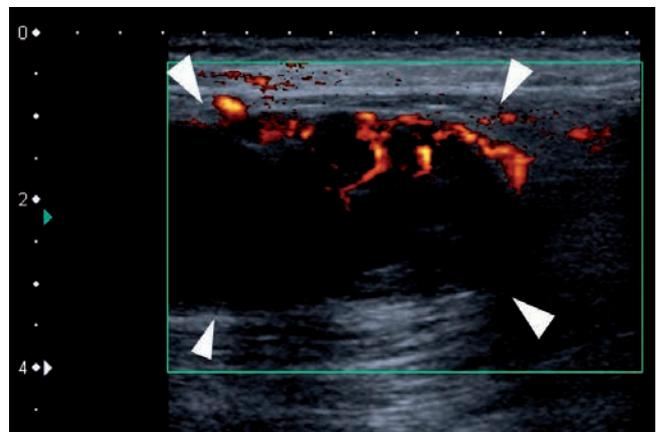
Ultrasound with power Doppler. A solid hypoechoic lesion (white arrowheads) with peripheral vascularity.
